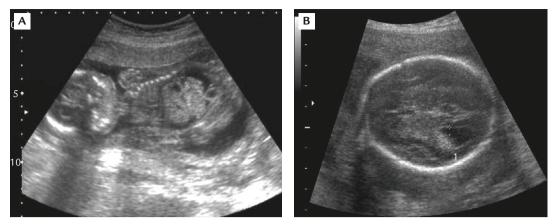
(A) Prenatal ultrasound at 20 gestational weeks shows fetal ascites. (B) Prenatal ultrasound at 22 gestational weeks shows ventriculomegaly.
